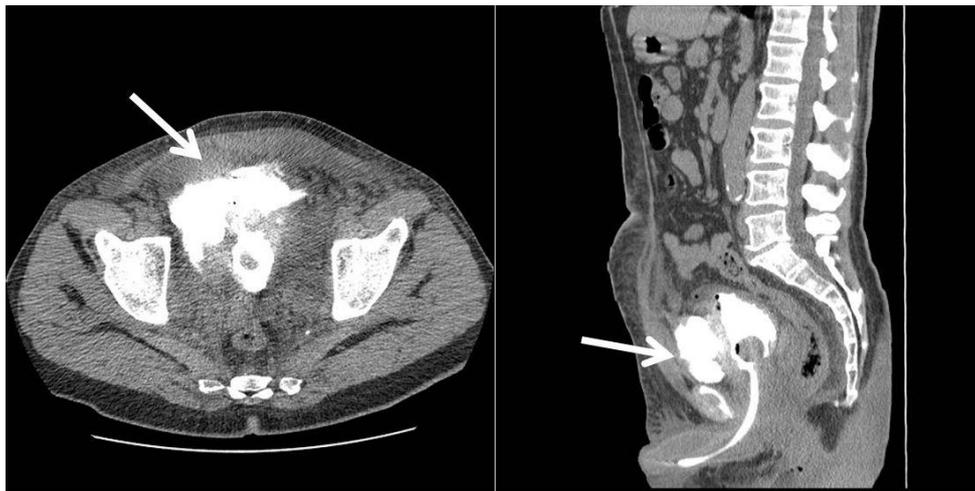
CT cystography of case two.
